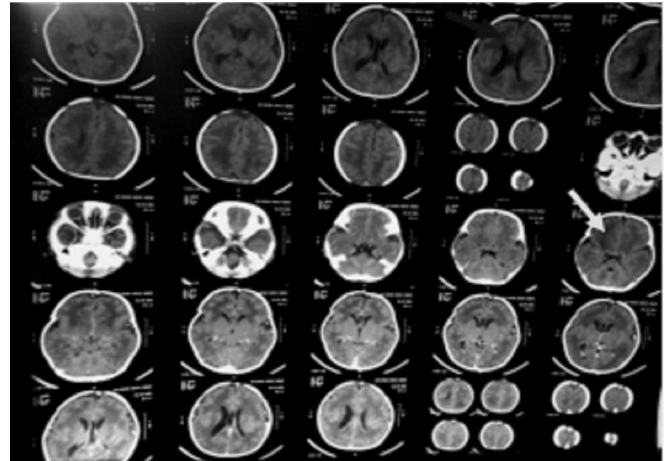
CT scan of brain showing hypodense subcortical white matter (red arrow) which was non enhancing after giving contrast (arrow).
